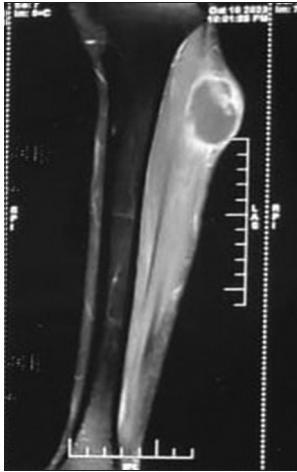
Magnetic resonance imaging shows post-contrast image T1 contrast FAT-SAT image. A mild peripheral enhancement of the capsule of the cystic lesion is noticeable, with the content remaining iso- to hypointense, showing no significant enhancement
